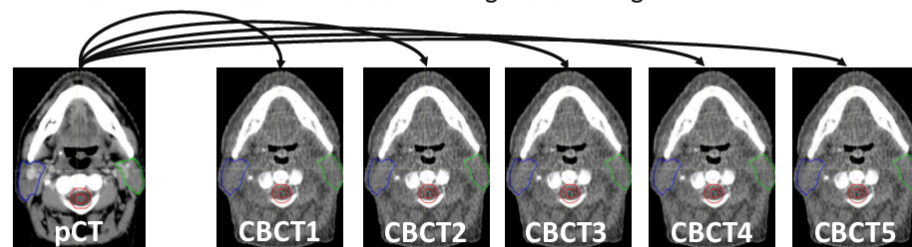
Contour propagations performed from pT to each of 5 CBCTs for the 5 applications.
